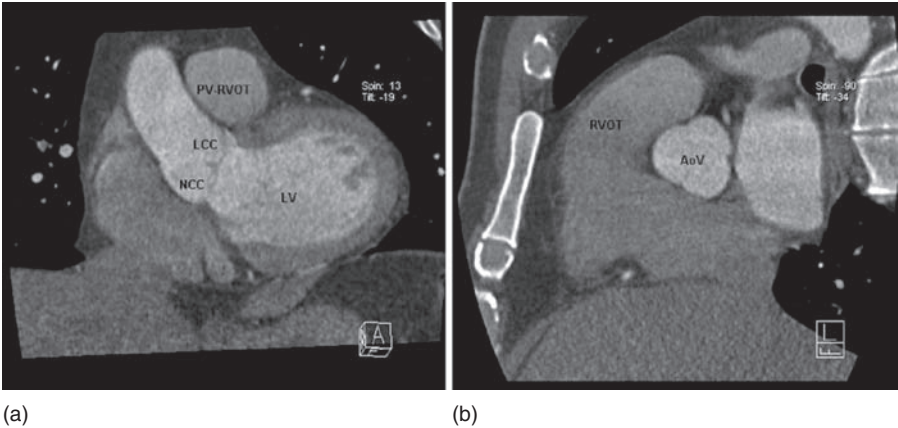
Cardiac CT scan with image cuts through the (a) pulmonary valve plane and (b) through the aortic valve plane. Note that the planes of the aortic and pulmonary valves are perpendicular.
